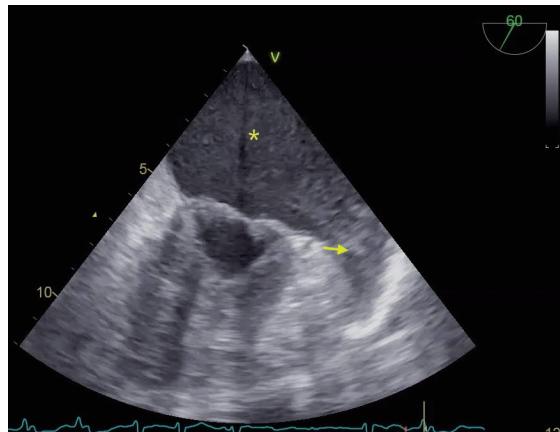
Transesophageal echocardiography revealed the presence of a thrombus within the left atrial appendage (arrow) along with spontaneous echocontrast in the left atrium (asterisk).
